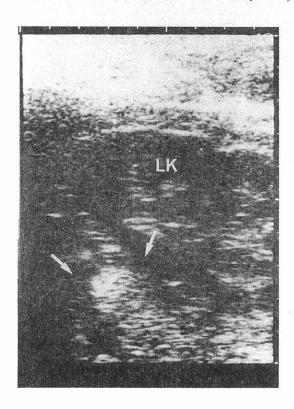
Posterior longitudinal real-time ultrasonography showed a left suprarenal mass (white arrows) which had high echogenicity centrally. LK=left kidney
